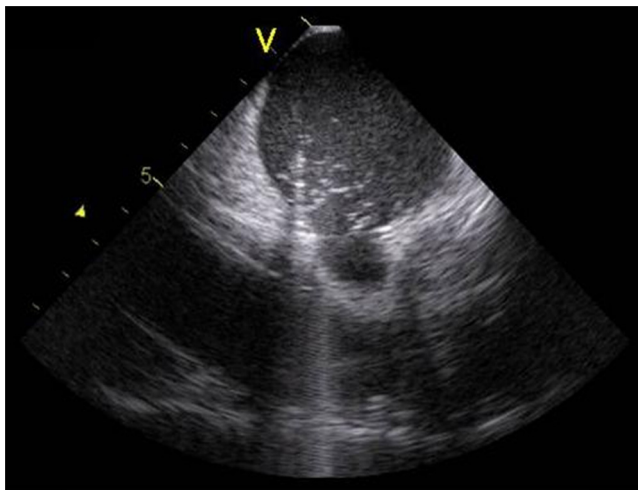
Intracardiac echocardiography. Contact of ablation catheter. Bubbles from catheter irrigation.
